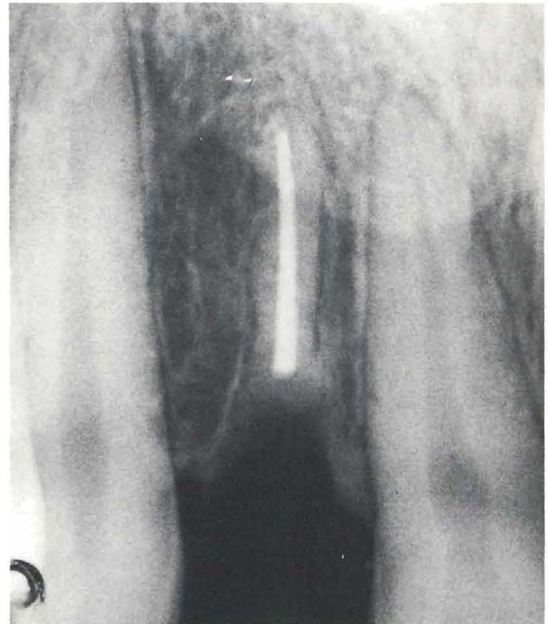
A radiograph taken almost five years after replantation. The tooth has been exposed to a new trauma, causing a root fracture and loss of the coronal fragment.
